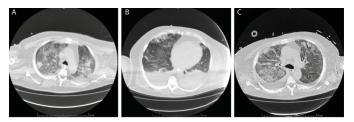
Chest CT scans. (A) Initial CT scan showing groundglass opacities with interlobular septal thickening (crazy paving). (B) Second CT scan showing a tendency of consolidation of bilateral pleural effusion. (C) Third CT scan (follow-up) showing a net reduction of ground glass opacities and pleural effusion.
